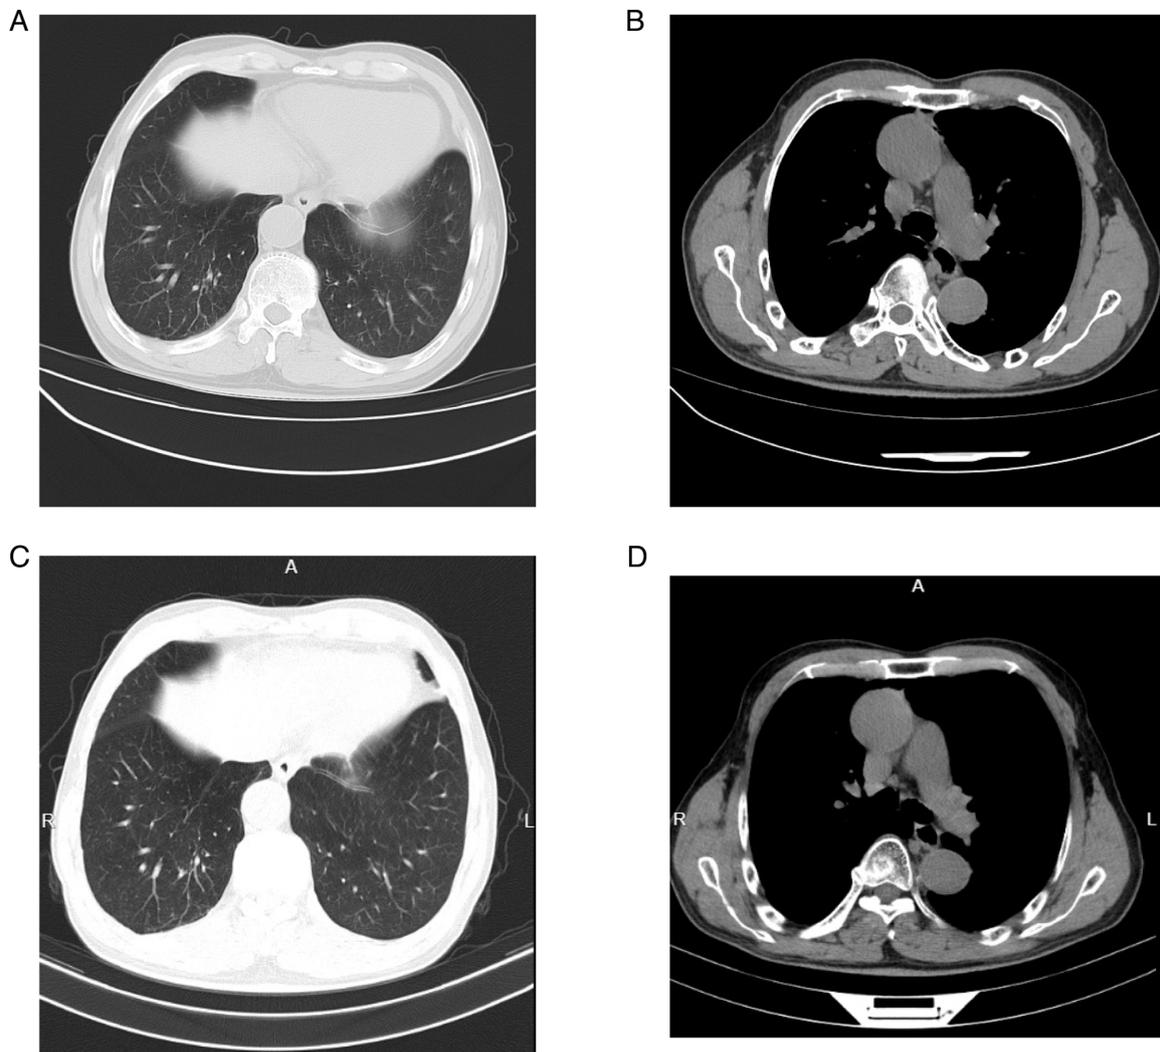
Results of the chest CT examination in March 2022. (A) A dense cord-like shadow in the lower lobe of the right lung, and (B) the thymoma results after resection. The results of the chest CT examination in October 2022 showed (C) no obvious abnormalities in the right lower lung, and (D) the thymoma results after resection. CT, computed tomography.
